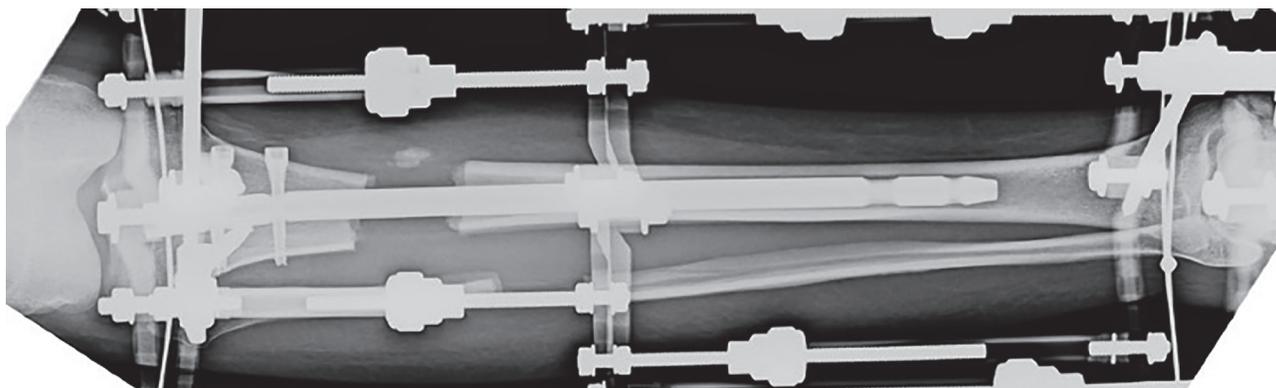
An x-ray of a patient during the lengthening period. Lengthening over an intramedullary nail technique has been used (right tibia). Note that a circular type external fixator is used for distraction of the tibia.
